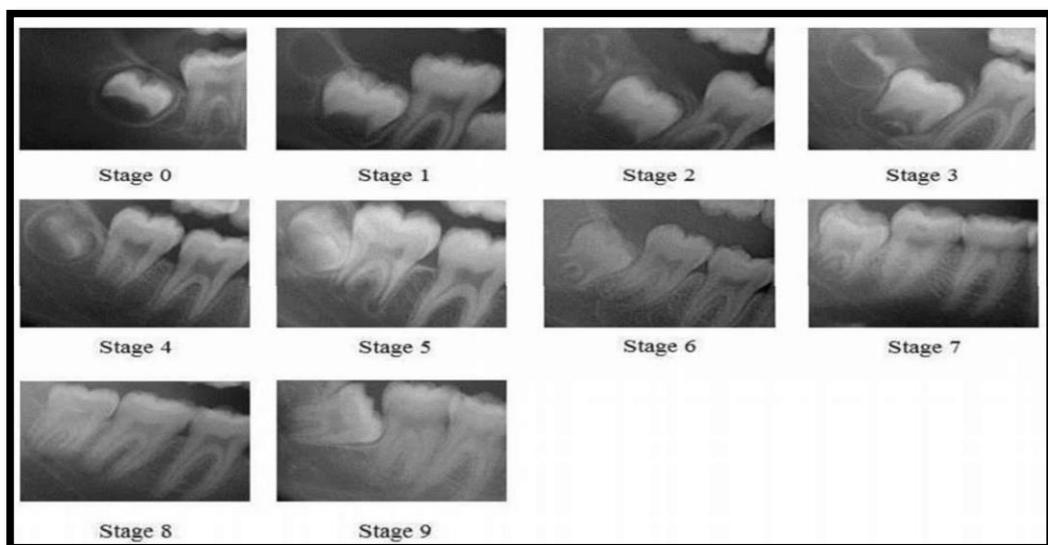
A radiograph of the different stages of development of the mandibular third
